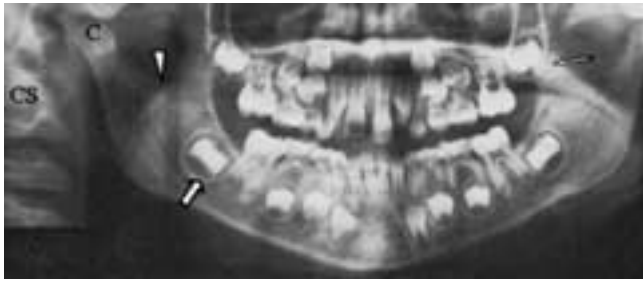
Panoramic radiograph of jaws in a child with mixed dentition (both primary and adult). Coronoid process (*thin white arrow*). Sigmoid notch of mandible (*arrowhead*). Mandibular condyle (*C*). Developing tooth bud of the permanent mandibular right first molar (*bold arrow*). Cervical spine (*CS*).
